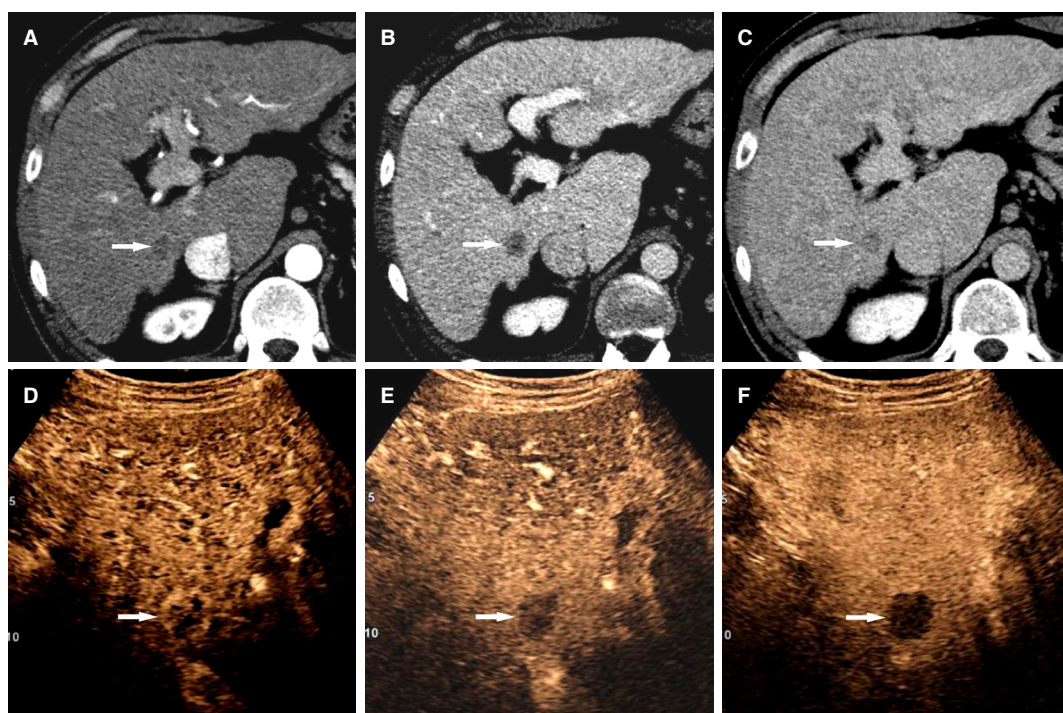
Intrahepatic cholangiocarcinoma in a 51-year-old man with hepatitis-C related liver cirrhosis. CT scans in the arterial (A), portal venous (B), and delayed (C) phases demonstrate a hypoattenuating hepatic nodule (arrow); C: the nodule shows a mild central enhancement in the delayed phase; D: CEUS in the arterial phase shows a rim arterial-phase hyperenhancement in the nodule (arrow); E: CEUS at 42 s after contrast injection demonstrates early washout (arrow); F: CEUS at 104 s after contrast injection shows marked washout (arrow). CEUS: contrast enhanced ultrasound
